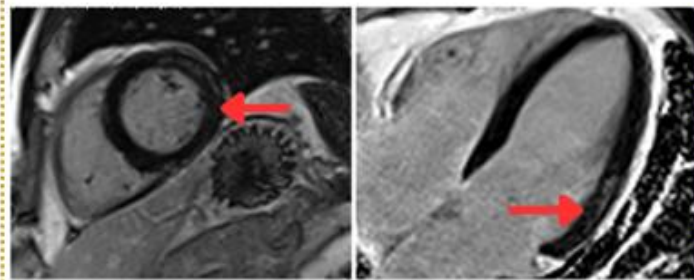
Cardiac MRI (CMR) showing subepicardial late gadolinium enhancement in the lateral wall (arrow), consistent with myocarditis
